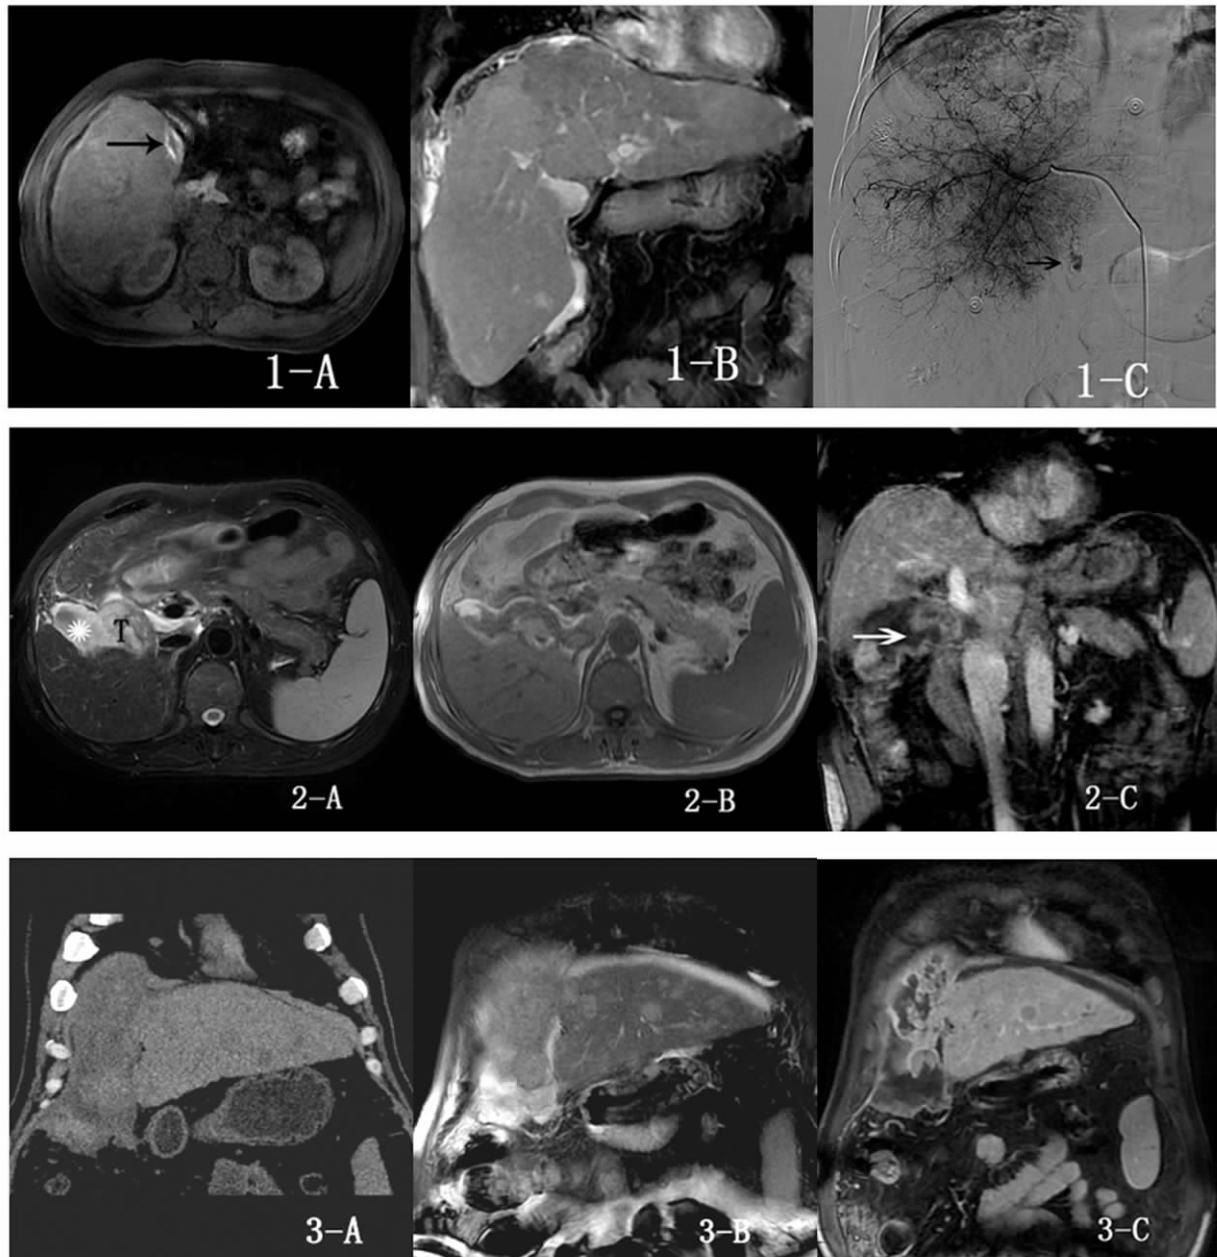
显示巨块型肝癌包膜下出血,出血表现为 T1WI 高信号(1-A)及 T2WI 高信号(1-B *),血管造影证实出血点位置(1-C);图 2 显示肝右前叶肿瘤破裂出血,肿瘤在 T2WI 为混杂高信号,与出血界限不清,"T" 为肿瘤,"*" 为出血(2-A),T1WI 显示肿瘤内有出血,并破裂至腹腔(2-B),肿瘤包膜及破口在冠状位延迟扫描显示清晰(2-C);图 3 显示肝左内叶多发肝癌,CT 平扫冠状位重建仅可显示出血破入腹腔,不能显示肿瘤边界及肿瘤破口、出血范围(3-A),T2WI 可显示肿瘤及出血范围,破口未能明确显示(3-B),冠状位延迟扫描肿瘤包膜不连续,破口显示清晰,出血范围及肿瘤边界清晰。
